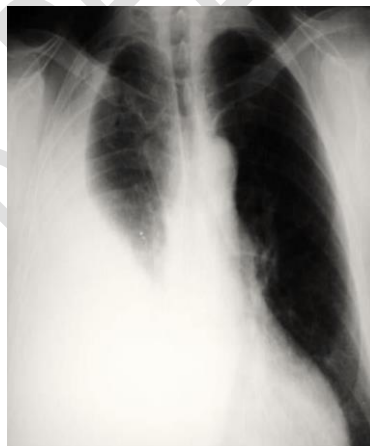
Chest X-ray showing a pleural opacity
